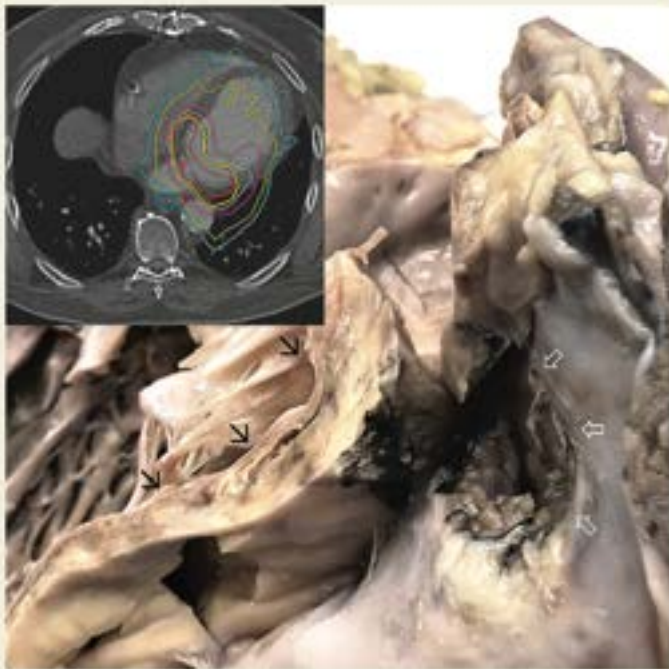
Post-mortem macroscopic picture of the myocardial substrate in the inferior wall (black arrow) and adjacent oesophagopericardial fistula opening through the parietal pericardium (open arrow). Inset: CT angiogram depicting radiosurgical treatment plan with isodose lines.
